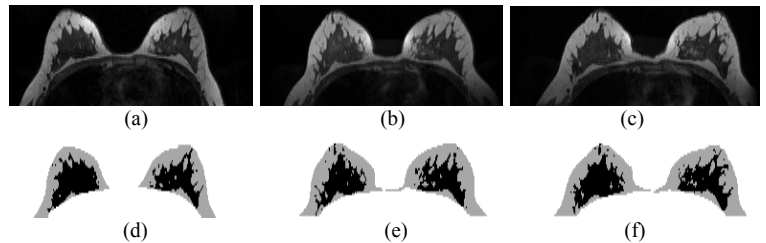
(a-c) T1-weighted axial images acquired and (d-f) fibroglandular tissue (black coloured area) classified inside the segmented volume (gray coloured area)
